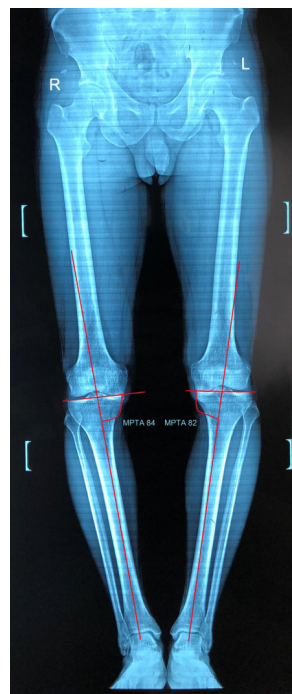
X-ray images showing the medial proximal tibial angle (A) 84° on the right and 82° on the left preoperatively and (B) corrected to 96° on the right and 94° on the left postoperatively.
